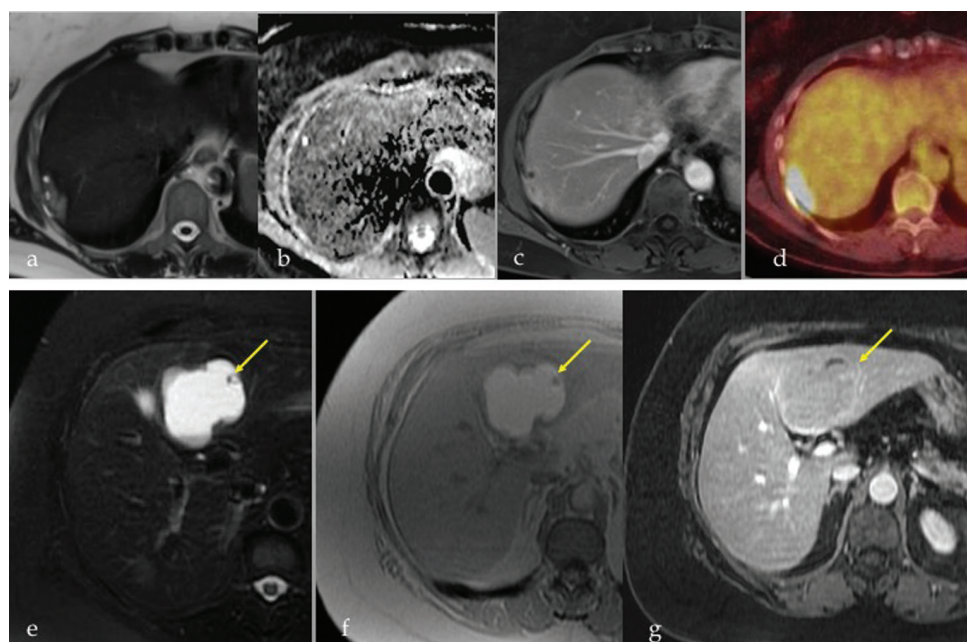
a. Cystic capsular metastasis from ovarian cancer on T2W magnetic resonance imaging. b. Apparent diffusion coefficient map which shows restricted diffusion. c. Post-contrast T1W magnetic resonance imaging shows internal enhancement. d. Positron emission tomography-computed tomography fused image showing intense fluorodeoxy glucose uptake. Biliary cystadenoma on (e) T2W magnetic resonance imaging, (f) pre- and (g) post-contrast magnetic resonance imaging. A mural nodule is seen (arrows) which shows enhancement. Internal contents are T1 bright suggesting mucin or blood products.
